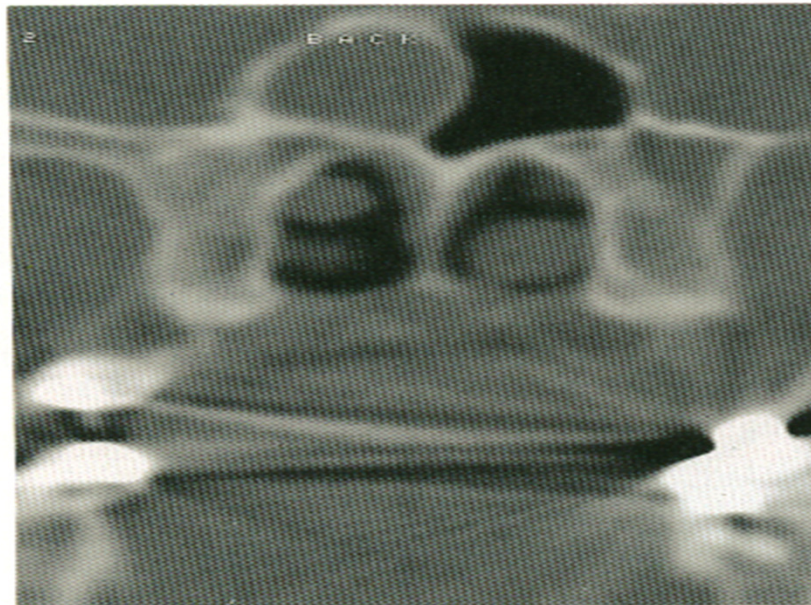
Sphenoid sinus mucocele on CT scan.
